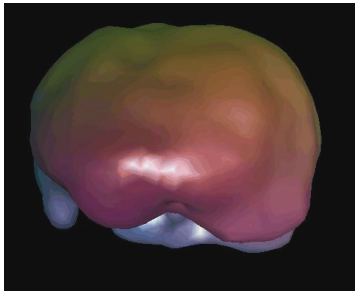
A 3D SPECT Brain Image from a drug dependent patient. This image was generated by the SPECT PICKER model located in Guillermo Almenara, Hospital Lima-Perú.
